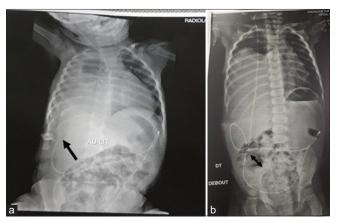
(a) Sleep chest and abdomen radiograph demonstrates that complete opacity in right hemithorax with cather tip is in contact of diaphrragm "black arrow," (b) the tip catheter is in peritoneal cavity on up postion. "Double black arrow."
